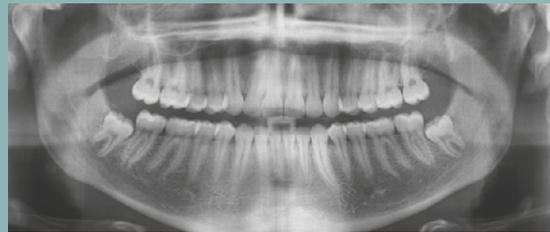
Final orthopantomography with good root inclination of maxillary posteriors after distalization. No root resorptions or pathologies are present, teeth 38, 48 were advised for extraction.
